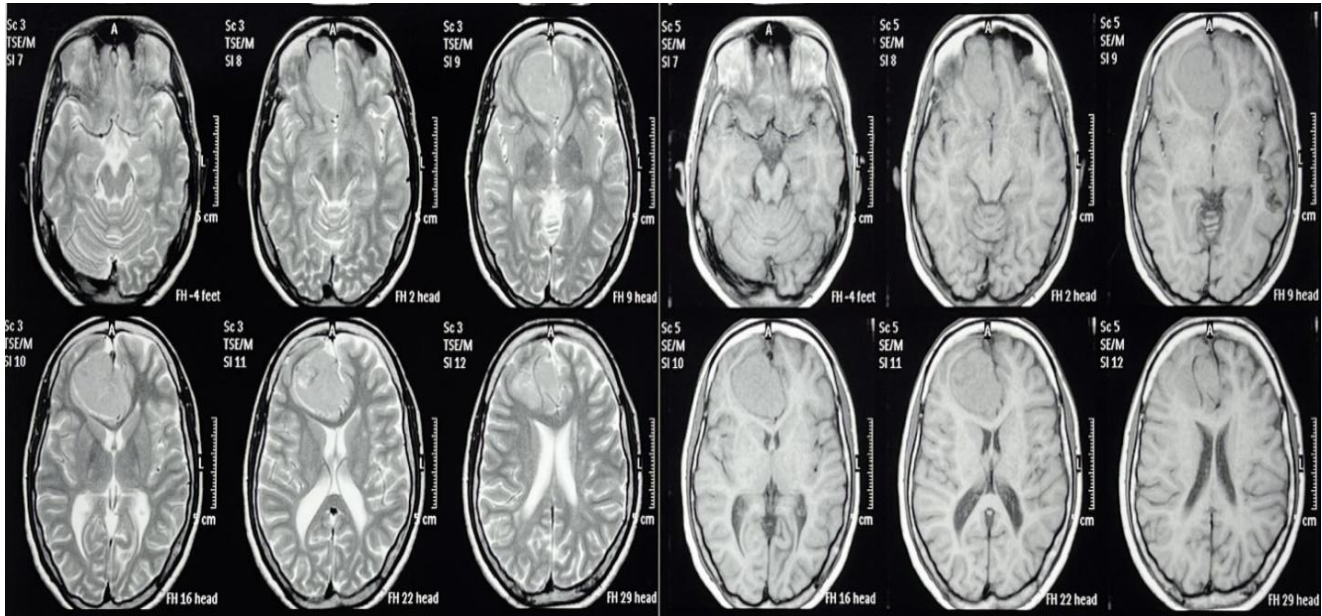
Magnetic resonance imaging of the brain revealed a well-defined extra-axial lesion along the anterior falx in right frontal paramedian location with mild edema in underlying white matter with mild mass effect suggestive of meningioma.
